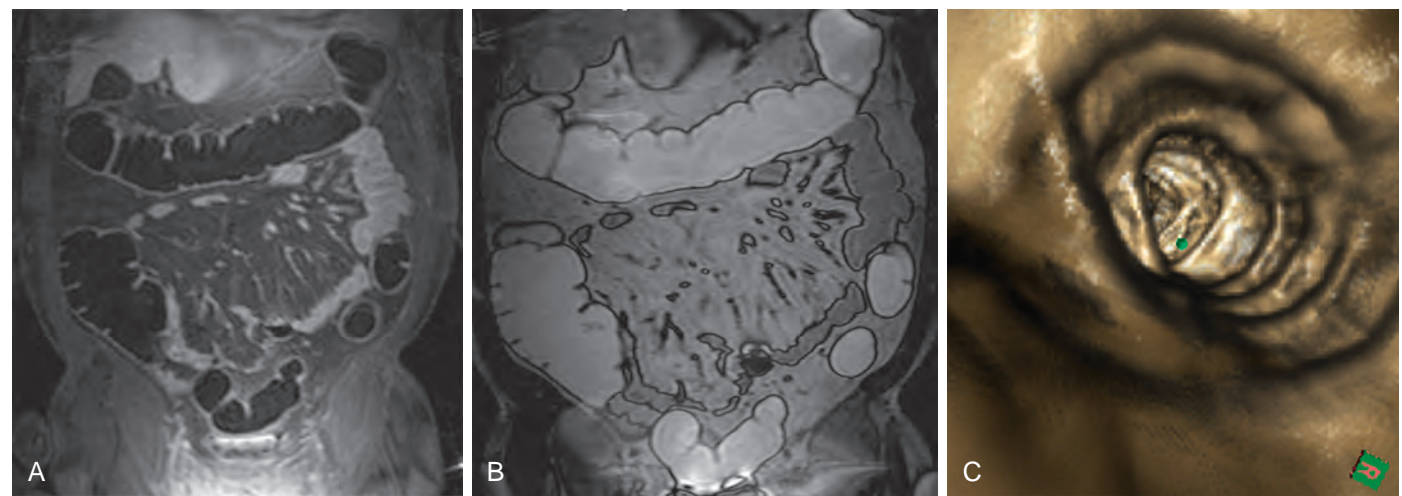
MRC sequences. Comprehensive examination protocol of MR colonography should include T1-weighted images (A), true FISP images (B), and virtual endoscopic reconstructions (C).
